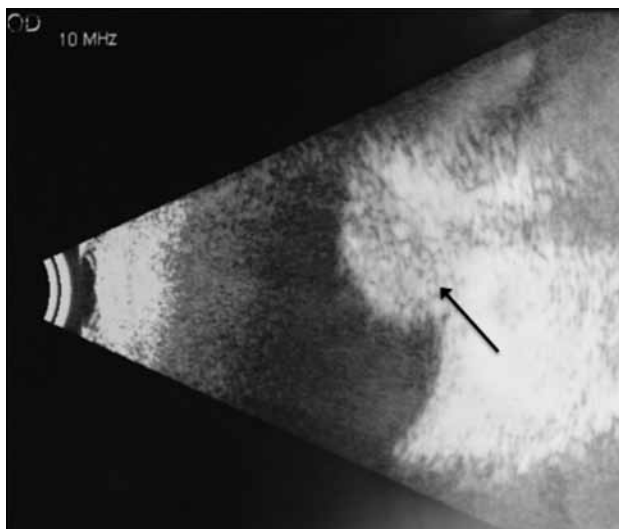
B-scan ultrasonography showing an echogenic choroidal mass with high internal reflectivity (black arrow indicates the choroidal mass). Courtesy of the Department of Ophthalmology, Caritas Medical Centre.
